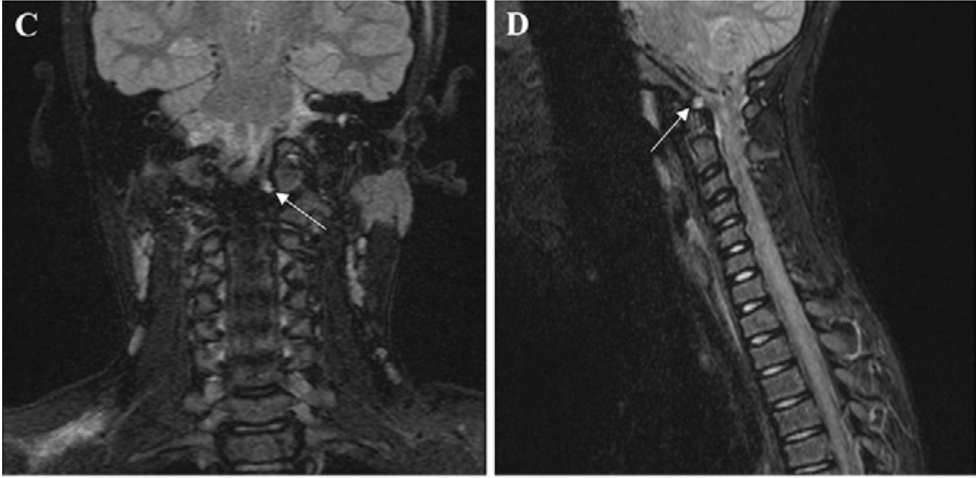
Case 1. Cervical radiograph (A) obtained on presentation, demonstrating lateral deviation of the odontoid process with no associated cervical spine fractures. Axial T2-weighted MRI (B), coronal STIR (C), and sagittal STIR (D) sequences obtained on the day of patient presentation, showing signal intensity within the left alar ligament (white arrows), Flexion (E) and extension (F) cervical radiographs obtained at the 1-month follow-up, demonstrating no signs of dynamic cervical instability.
